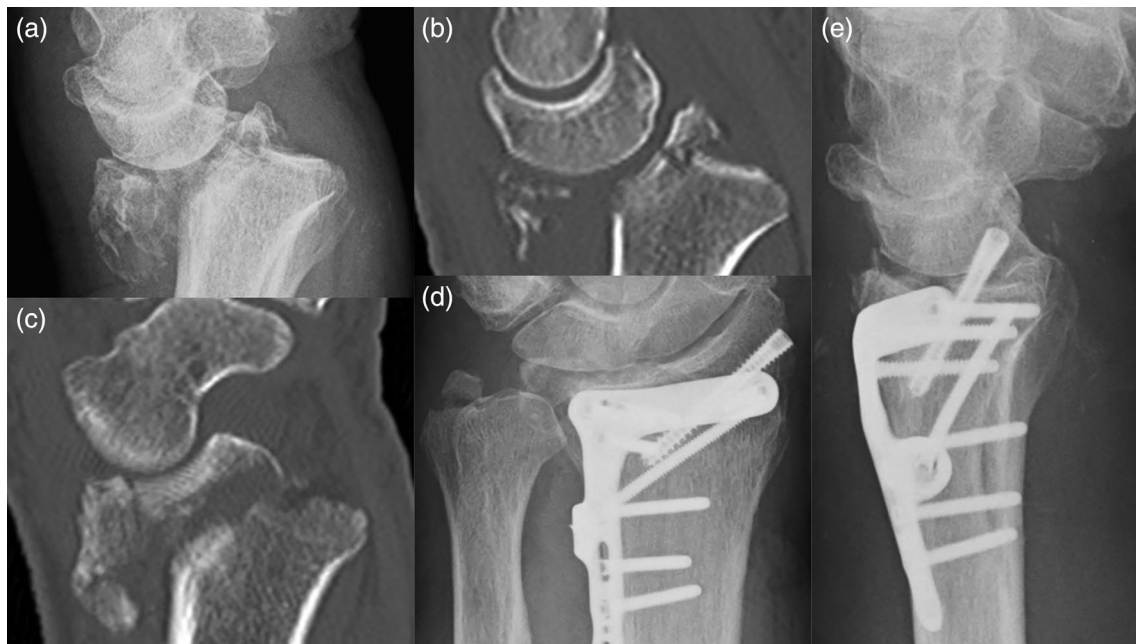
Type II injury (a) lateral radiograph and (b) CT sagittal view showing large dorsal and small volar fragment with (c) a styloid fracture (d) PA and (e) lateral views post-fixation using dorsal approach to fix with dorsal rim plate and percutaneous styloid screw. Also, note styloid fixation with the screw through the proximal ulnar hole of the plate. No volar approach was taken in this case as wrist was stable post fixation and ulnar styloid fracture was also managed conservatively.
